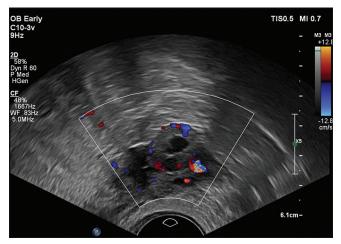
Transvaginal ultrasonography of a right adnexal mass with fluid echo and affluent Doppler flow around and visible fetus heartbeats before treatment
